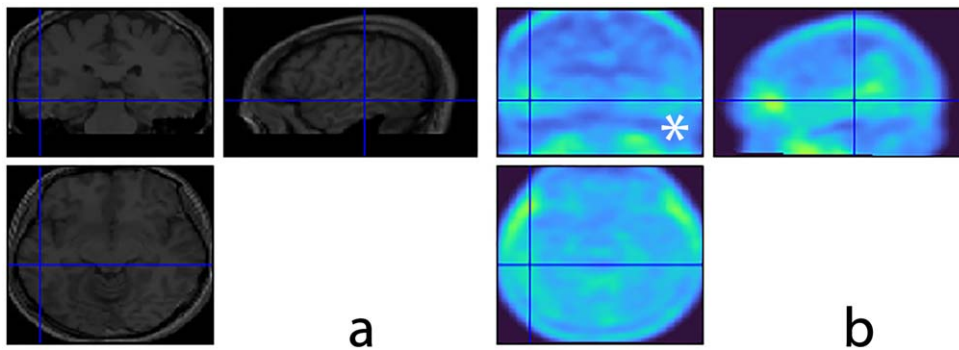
Exemplification case 6. Template MRI in (a) and co-registered PET tau imaging in (b) show a mild burden of tau protein in the right temporal lobe (blue cross). To note that a very mild uptake, slightly superior to the background, is detectable in the left temporal lobe as well (b, white asterisk).
